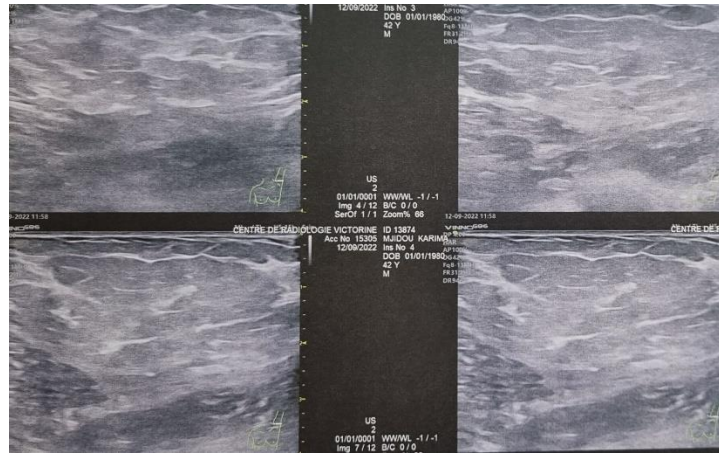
ultrasound appearance of axillary lipomatous hypertrophy
